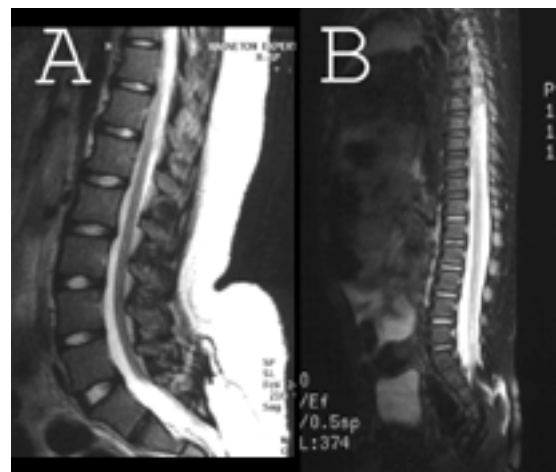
Sagittal MR images demonstrating a lipomyelomeningocele. A: The spinal cord extends to the level of the sacrum. An associated superficial subcutaneous lipoma is discernible. B: The spinal cord extends to the level of the sacrum. A syrinx is present.
